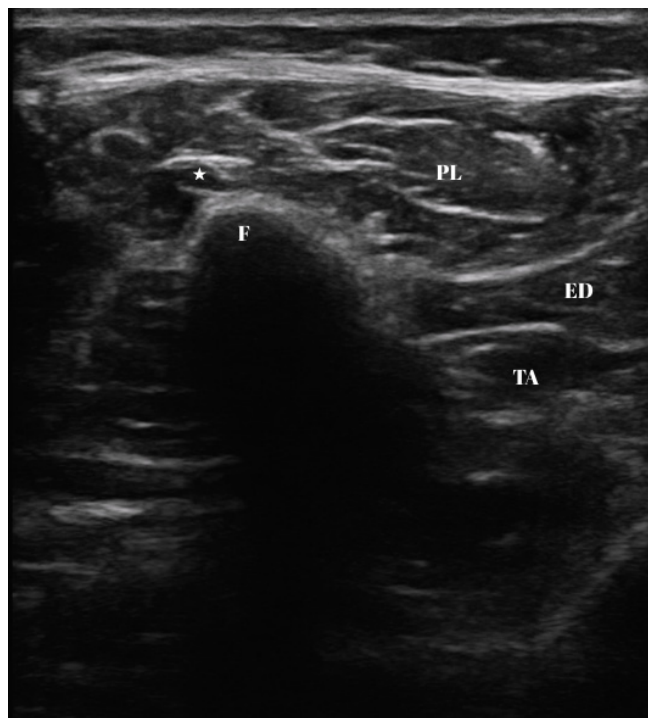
Short-axis ultrasound image at the entrance of the peroneal tunnel. The white star marks the common peroneal nerve. PL – peroneus longus muscle; ED – extensor digitorum muscle; TA – tibialis anterior muscle; F – fibula
